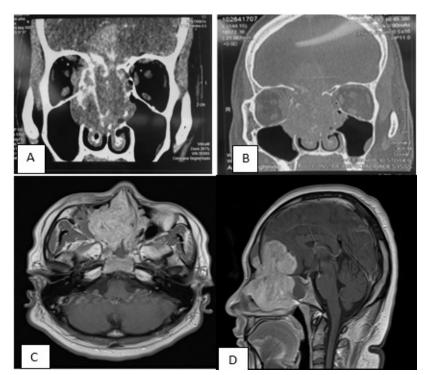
Tomography of paranasal sinuses in coronal cut (A) with contrast and (B) without contrast. It was observed a mass of soft tissues with infiltration, destruction and extension to both maxillary sinuses, medial walls of the orbits and displacement to the right medial rectus muscle laterally. Cerebral magnetic resonance imaging (C) T1 axial cut and (D) sagittal cut with ferromagnetic contrast (gadolinium), which showed an avid enhancement of the lesion, of infiltrating characteristics to cribriform lamina and frontal bone with extension to right intraconal region. It had no local extension to cervical or thoracic nodes (data not evaluable in cuts presented).
